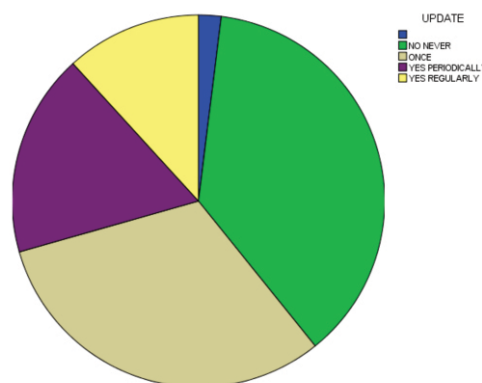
Further Graduate Training in Radiography
